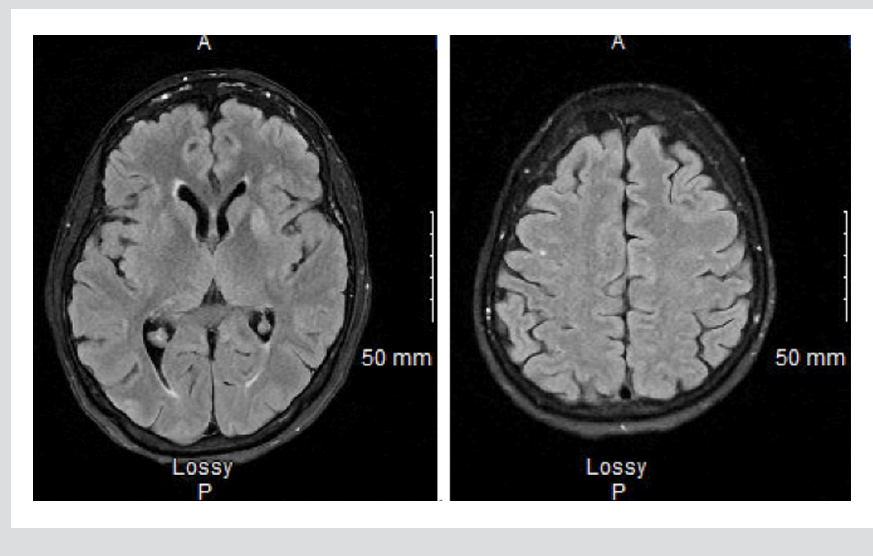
Repeat Magnetic Resonance Imaging Obtained Four Weeks Later Showing Progressive Cortical and Basal Ganglia Signal Abnormalities
